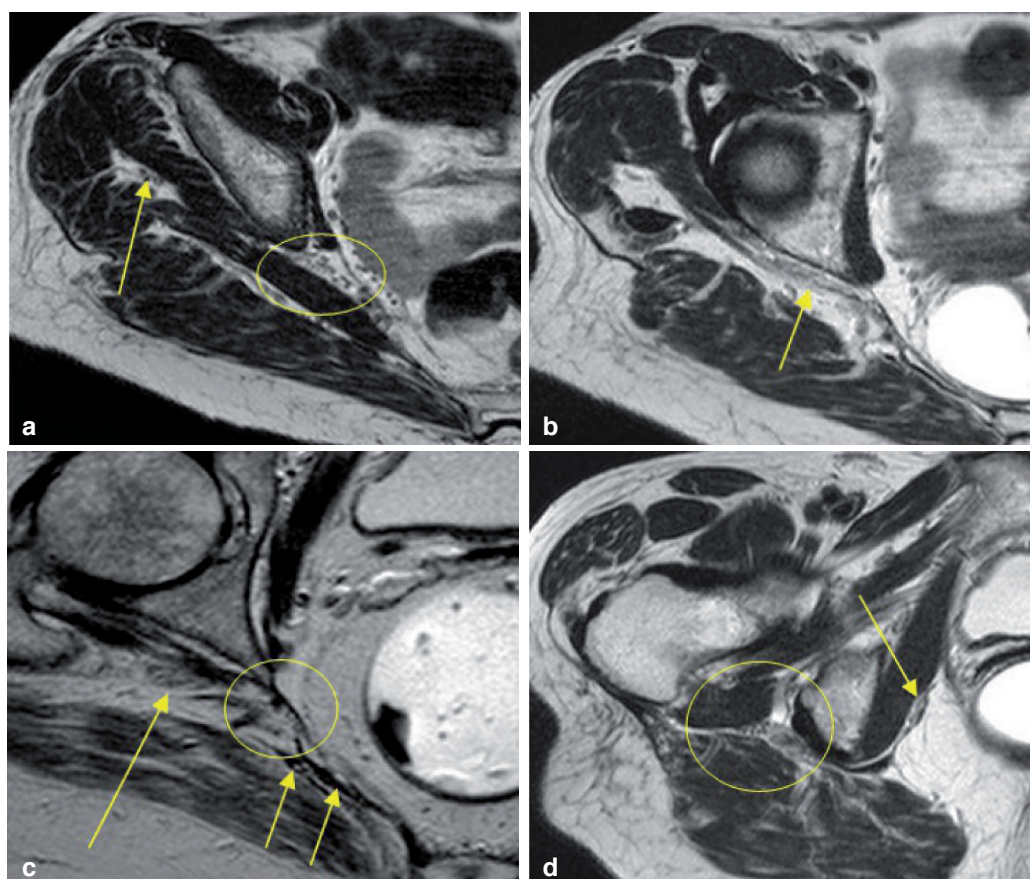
Standard axial T2-W MR image (a) of the right half of the pelvis taken at the level of the ischial margin (level I) showing the “dark dots” appearance of the lumbosacral nerve (circle) just anteriorly to the piriformis muscle. The gluteal nerve (arrow) is also seen between the gluteus medius muscle, anteriorly and the gluteus maximus muscle, posteriorly. A section obtained at the level of the ischial spine (b) and greater sciatic foramen (level II) shows the nerve after exiting the pelvic cavity (arrow) as an indistinct, elongated dark structure almost iso-intense with the piriformis tendon. A section obtained at the level of the acetabulum (c) and head of femur (level III) shows the sciatic nerve (long arrow) as a more oval-shaped structure resuming its dark dots appearance. At this level the pudendal nerve reenters the pelvic cavity (circle) after encircling below the space between the sacrospinous and the sacrotuberous ligament (double short arrows). A section taken at the level of the ischial tuberosity (d) consistent with level IV shows the sciatic nerve travelling in its narrowest space (circle) between the quadratus femoris muscle and the gluteal crease. The neurovascular bundle in the Alcock’s canal (arrow) is seen as a dark hypointense linear stripe just medial to the inner border of the obturator internus muscle.
